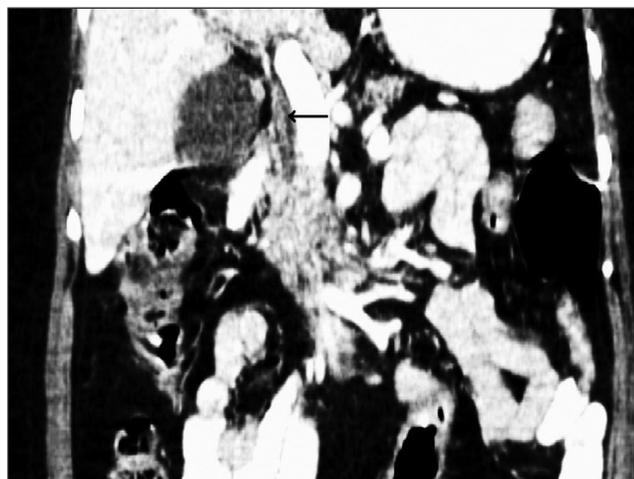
CT scan of the abdomen showing pneumobilia with a linear filling defect (Arrow) within the common bile duct.
